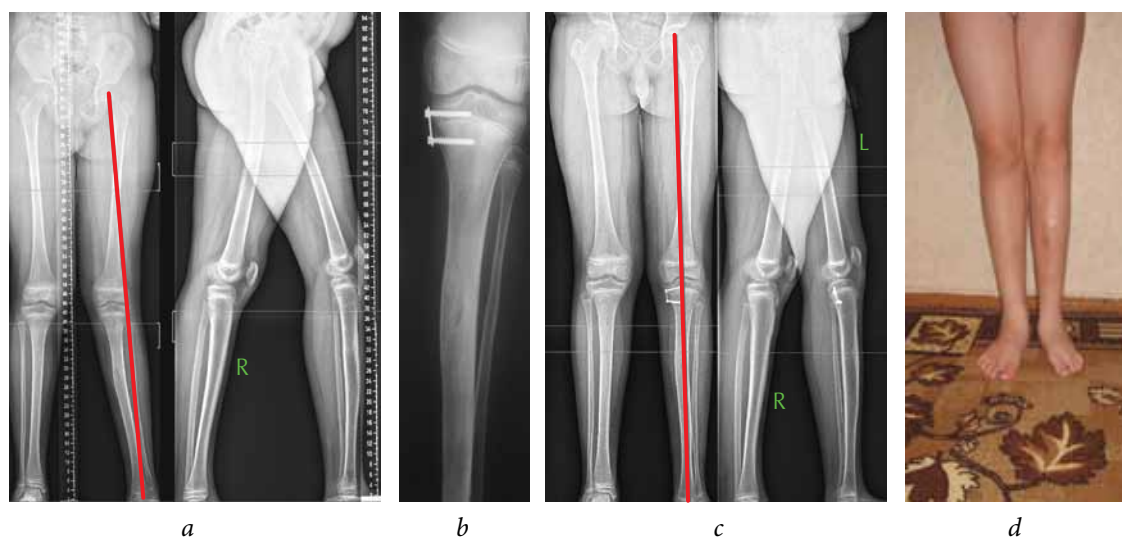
Patient R. at the second stage of surgical treatment: *a* — panoramic radiographs of the patient before the surgery; *b* — radiographs of the patient after the surgery; *c* — panoramic radiographs of the patient before plate removal; *d* — photo of the patient after plate removal
